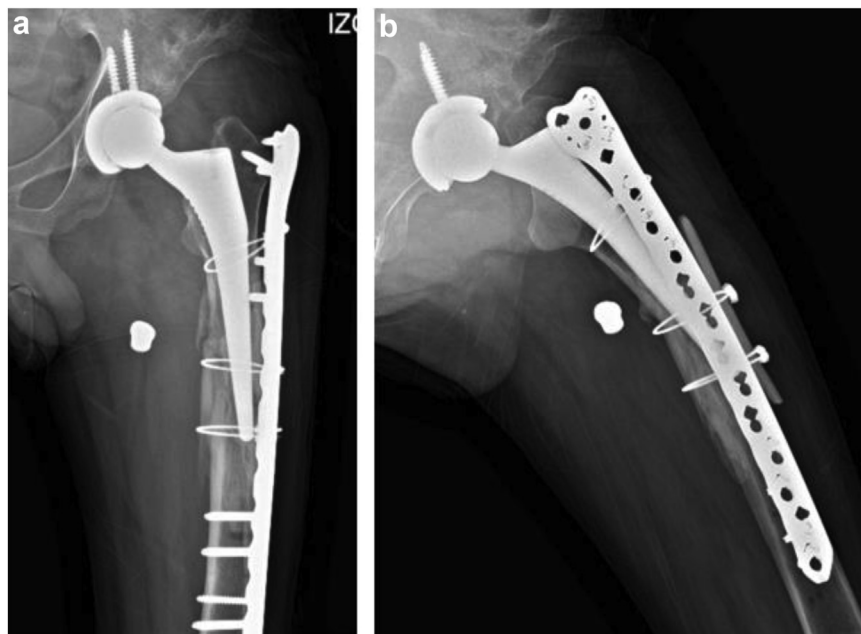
Postoperative (a) anteroposterior and (b) oblique proximal femur radiographs show bone union.
